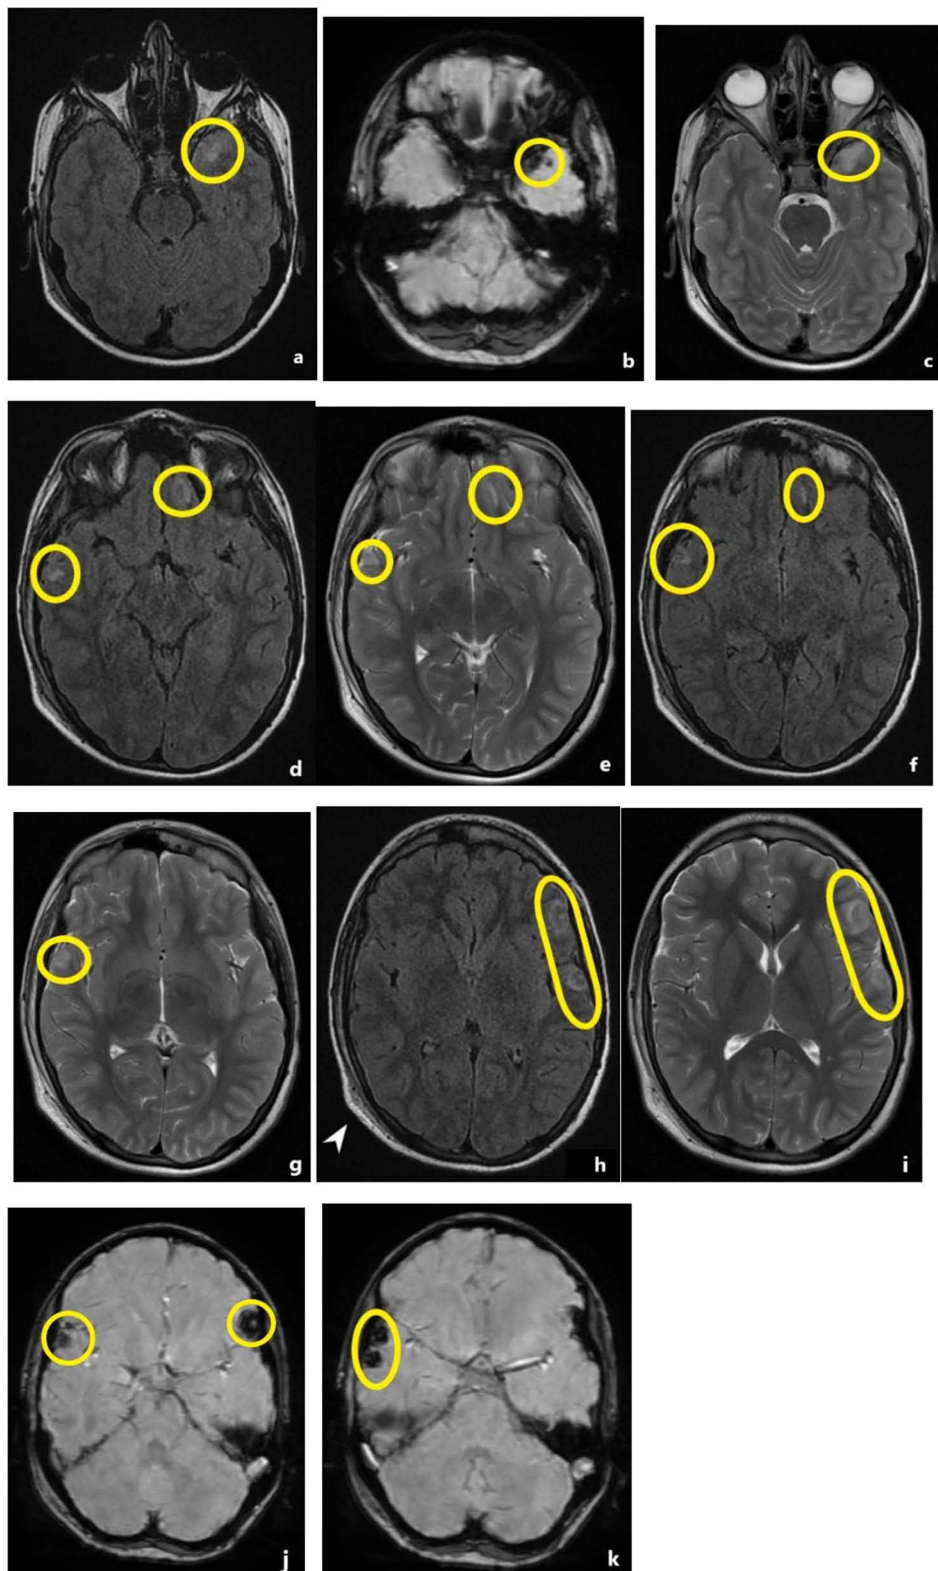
Right occipital epicranial hematoma (white pointed arrow h). All images show case bilateral cortical contusions on different MR sequences. (a, d, f, h) FLAIR sequences depicting hyperintense signal areas consistent with CCs (yellow circles and capsule). (b, j, k) SWI sequences display the same lesions with hypointense signal (yellow circles and capsule). (c, e, g, i) CCs with hyperintense T2 signal (yellow circles and capsule). (d, e, f) Left frontal non-hemorrhagic traumatic axonal injury (yellow circles and capsule). (d, e) FLAIR sequences; (f) T2-weighted sequences. (h-i) The epicranial hematoma located in the right occipital area pinpoints the force impact; high-signal FLAIR and T2 lesions support the “contrecoup lesions” diagnosis (yellow capsule).
